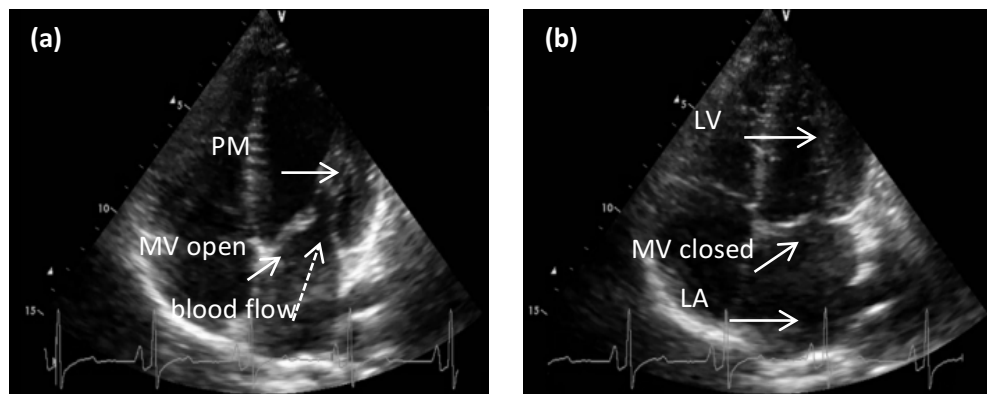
2D echocardiogram of a healthy mitral valve (a) direction of blood flow through open mitral valve (MV), papillary muscles (PM) (b) left atrium (LA), closed mitral valve (MV), left ventricle (LV) (acknowledgements: Gibbons R, Brunel University London).
